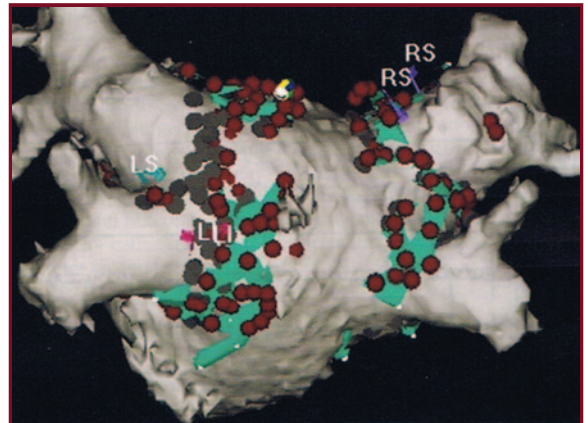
Combined electroanatomical map with CT scan during catheter ablation of left atrium. The red and green tags are the energy delivered ablation site. RS: Right superior pulmonary vein, LS= Left superior pulmonary vein, LI: Left inferior pulmonary vein.
